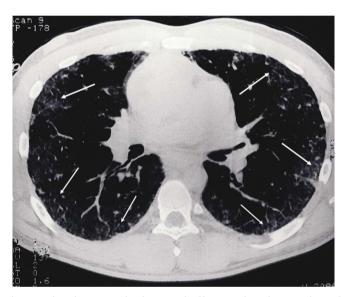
CT chest showing peripheral interstitial infiltrates, with patchy areas of ground glass and reticular opacities (arrows).
